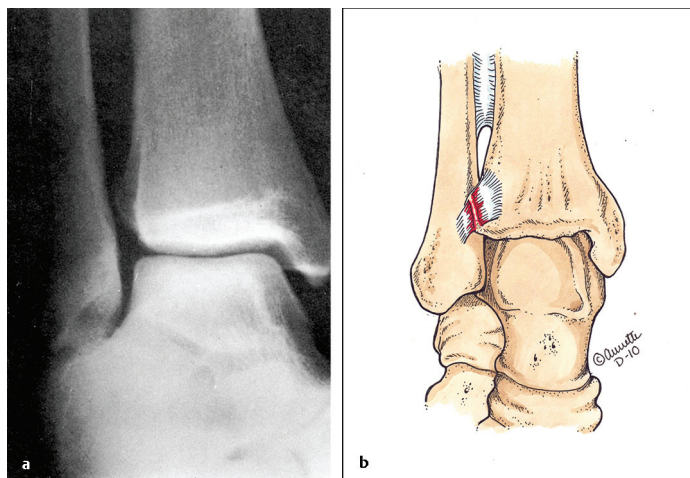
(a) Radiograph showing increased space between the tibia and fibula. (b) Rupture of the anteroinferior tibiofibular ligament. (This image is provided courtesy of Annette Dahlström.)
